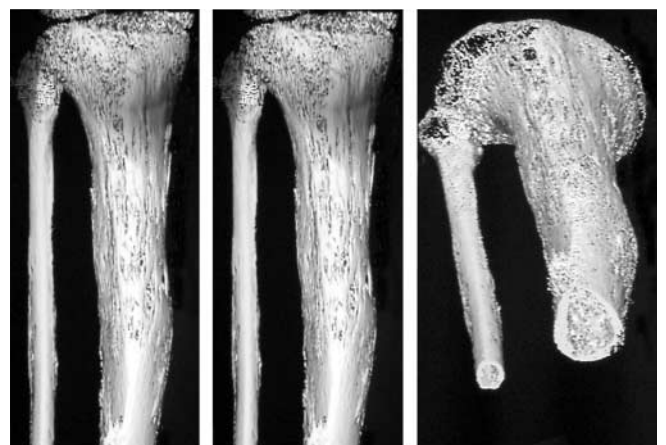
Same case as in Fig. 1. Three-dimensional CT images 624 days after the completion of transport. Cancellous bone of the medullary canal of the regenerated segment is evident
